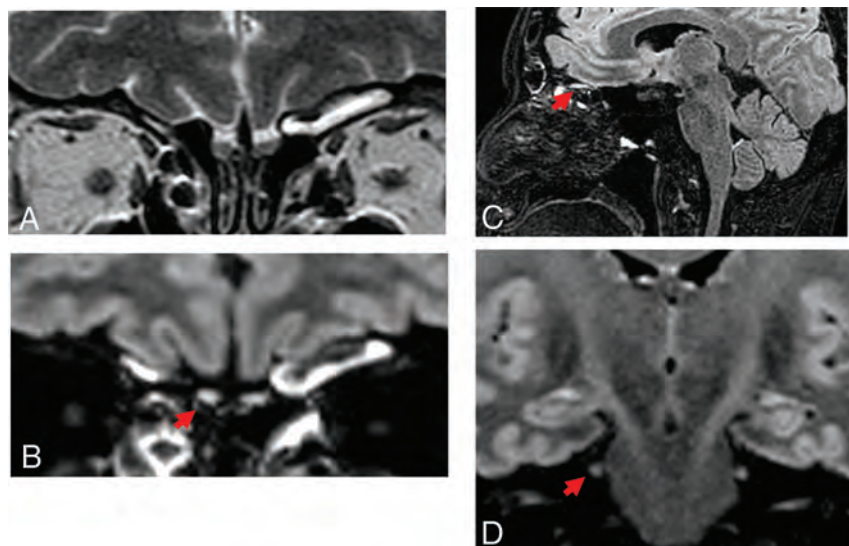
A 48-year-old woman positive for COVID-19 who presented with weakness and unsteady gait of 1 week's duration. Neurologic examination was significant for truncal ataxia, dysarthria, and left-sided dysmetria. *A*, Coronal high-resolution T2WI demonstrates normal OB morphology and signal intensity. *B*, Coronal and *C*) sagittal postcontrast T2 FLAIR images demonstrate an increased T2 signal within the OB (red arrows). Note relative increased signal compared with *D*) coronal T2WI at the level of the intracisternal segment of the trigeminal nerve (red arrow).
